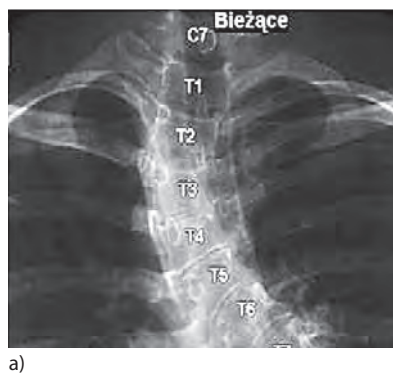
Numeric labeling on standing PA and lateral radiographs from the cervical part of the spine (see in text)
